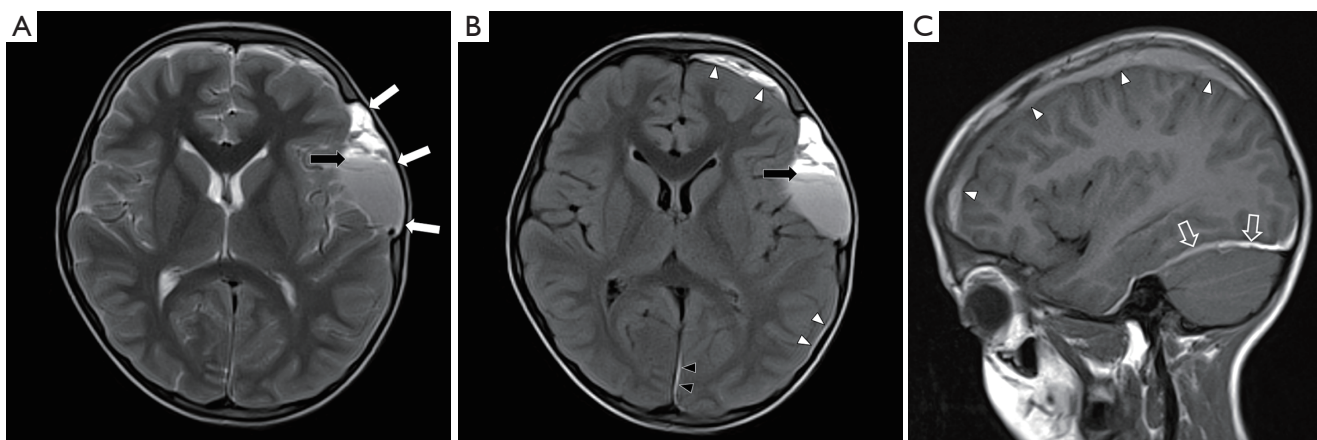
(A) Axial T2-weighted, (B) axial FLAIR and (C) sagittal T1-weighted sequences of the brain. There is a cystic extra-axial lesion in the left middle cranial fossa containing a fluid-fluid level (black arrow). The location and morphology of the lesion is consistent with an arachnoid cyst. On the FLAIR sequence, the signal within the cyst does not suppress, suggesting intracystic haemorrhage. There is also subdural blood overlying the left cerebral convexity (white arrowheads), within the posterior interhemispheric fissure (black arrowheads) and along the tentorium (open arrows). The overlying skull vault is thinned (white arrows) and there is an absence of sulcal effacement or midline shift despite the size of the lesion. These features are indicative of a longstanding process which has remodeled the adjacent skull vault and brain parenchyma.
